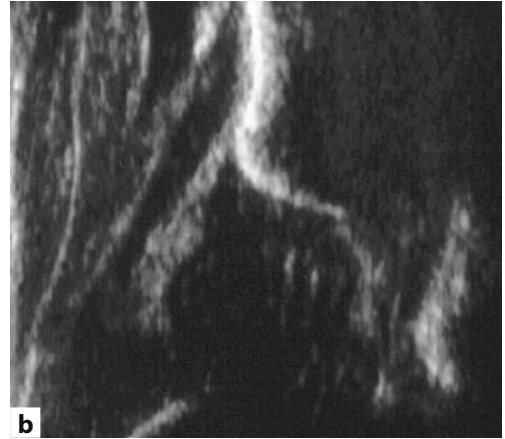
a The probe in this example is tilted anteriorly and the direction of the ultrasound beam is postero-anterior. b The image is produced while tilting the probe anteriorly, as shown in a. The image plane misleadingly appears to be posterior only because of the tilted probe. Compare with a correctly executed image in Fig. 12.1c
